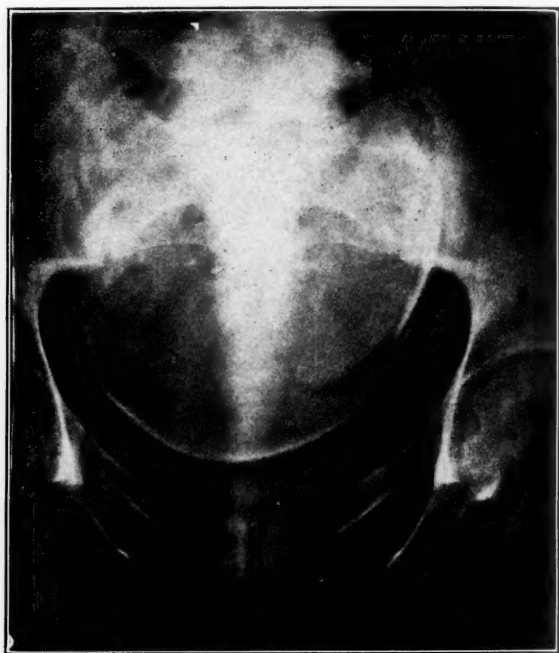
Anteroposterior roentgenogram showing the head, R. O. P.-R. O. T. position, descending through the posterior pelvis as far removed as possible from the symphysis, A. Type of pelvis android.
